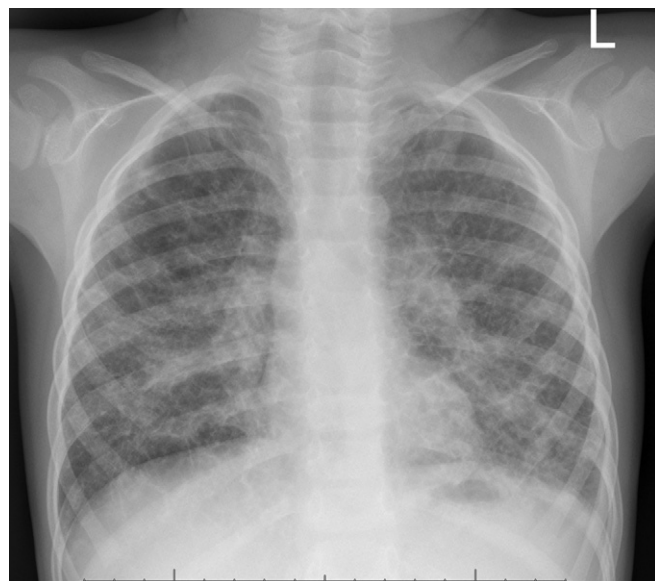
Chest radiograph at presentation. Basal consolidation in the left lower lobe, opacification along the left lateral wall and mediastinal shift, indicating pneumonia and pleural effusion. Reticulonodular pattern in right lung and left upper lobe.
